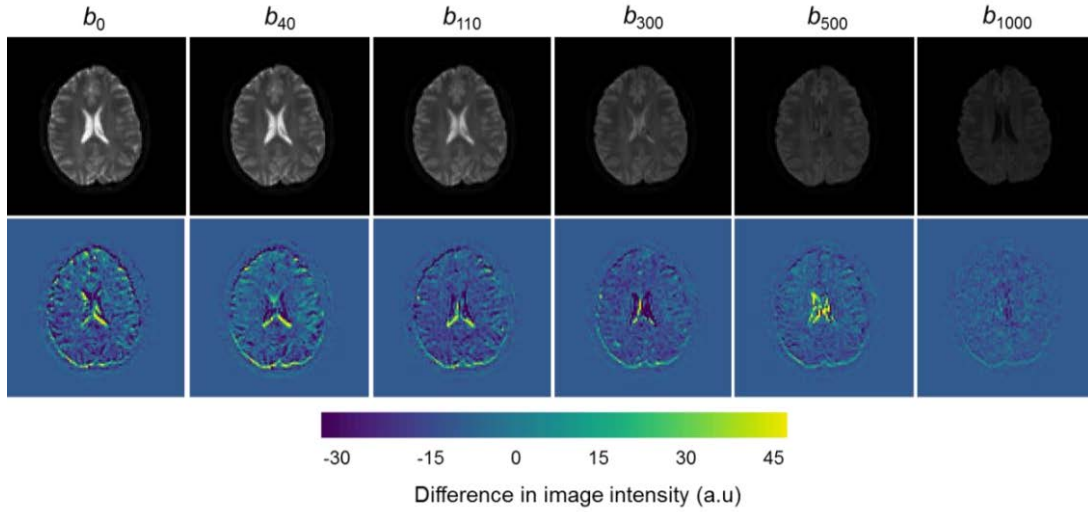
The difference images of b -values used for the computation of SNR. The diffusion-weighted images (top) and the difference images, [im3], (bottom) for a series of b -values used in the DW-MRI protocol.
